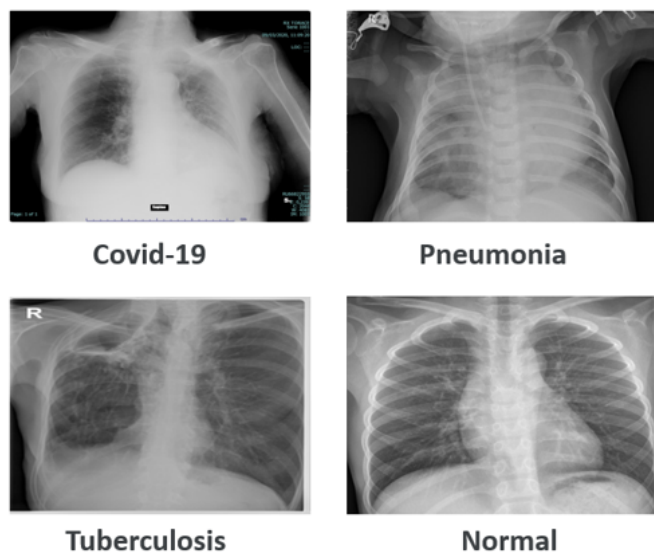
Samples belong to the Chest X-Ray dataset from each class
